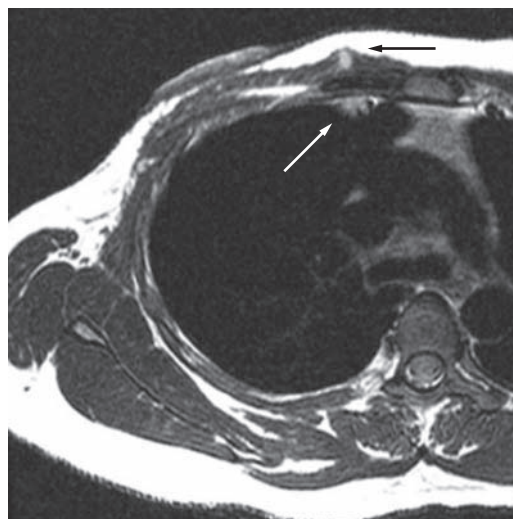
Breast MRI with ultrasmall superparamagnetic iron oxide demonstrates both the enlarged right internal mammary node (white arrow) and right chest wall lesion (black arrow) with hyperintensity, indicating a tumor.
